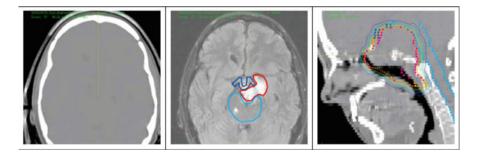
Example of treatment planning images for the treatment of a patient with a skull base chordoma using carbon ion radiotherapy (CIRT). The *left image* shows the CT data used for dose calculation, the *image in the center* shows a T1-weighted MR image of the same anatomical location, which is colocalized with the CT data set and is used for the delineation of the tumor and organs at risk. The *deep* and *light blue contours* represent the optic chiasm and brain stem, respectively, the *red line* the target volume. The *image on the right* depicts the dose distribution on the CT image resulting from two opposing fields of carbon ions. The *red*, *yellow*, *green* and *blue lines* represent the 90%, 70%, 50% and 30% isodose, respectively
